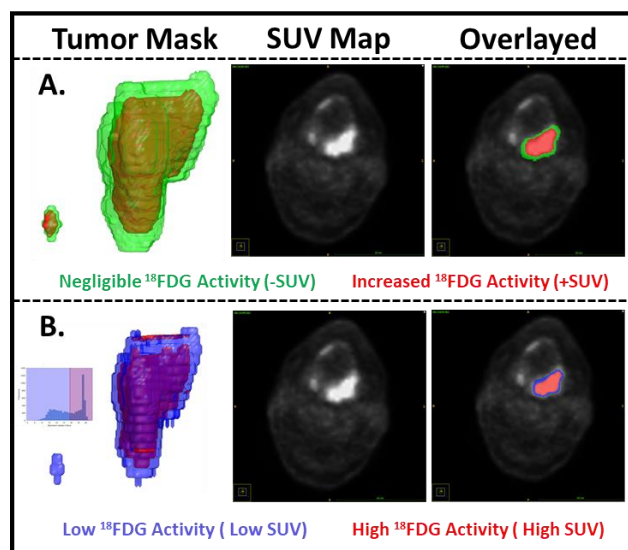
Regions of different FDG uptake avidity as defined by the PET SUV map. A. For Experiment 1A, the tumour contour (red) was dilated by a factor of 2 at its centroid. The two concentric regions represent areas of elevated FDG uptake (red) and negligible FDG uptake (green), respectively. B. For Experiment 1B, the tumour was divided into two sub-regions based on the FDG uptake avidity, using 50th Percentile of SUV (SUV₅₀) as the threshold.
